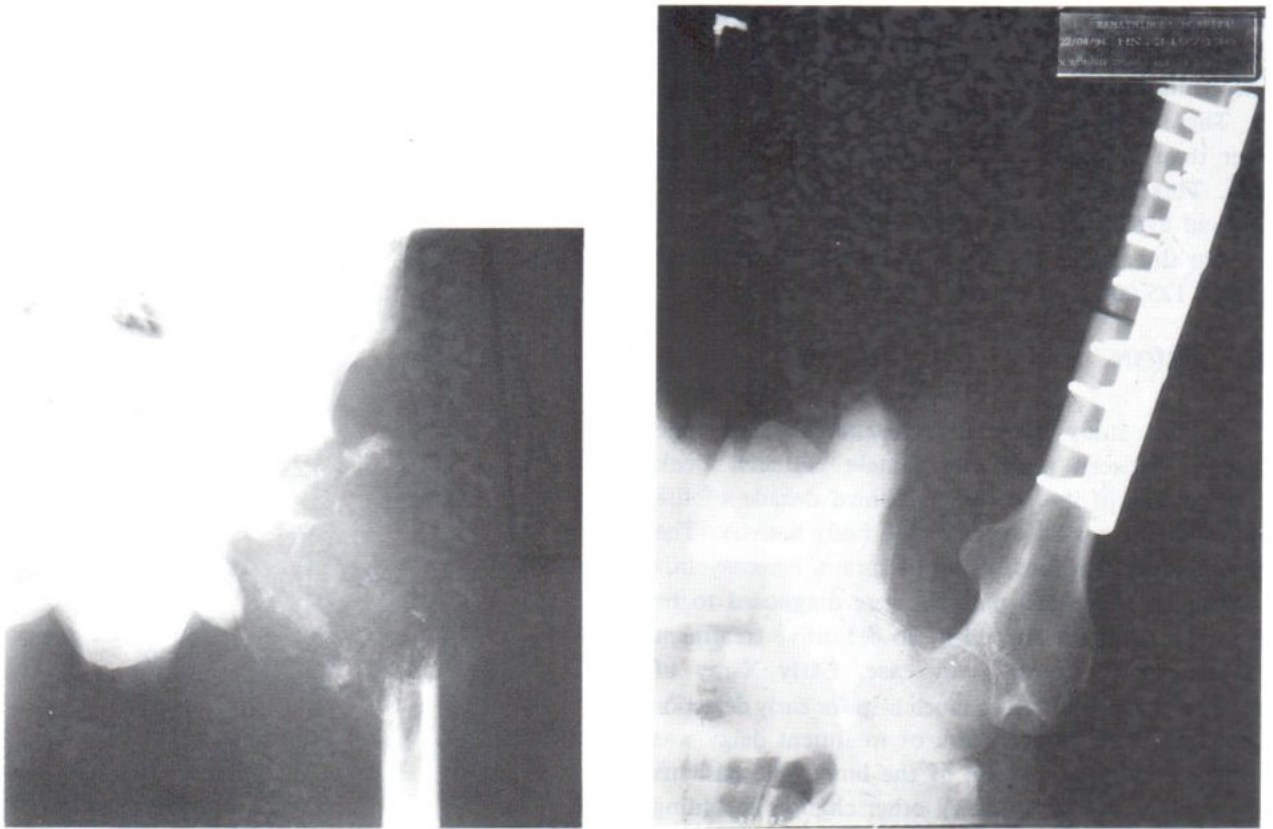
Plain film of a patient with upper femur lesion, he was undergone preoperative chemotherapy with limb salvage surgery.
